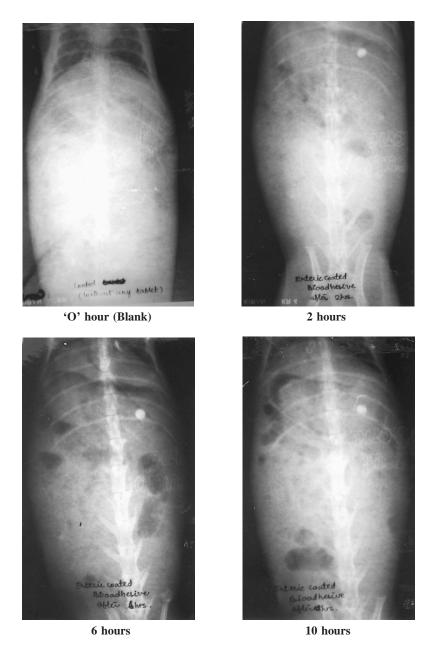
X-ray photographs taken after administering the enteric-coated bioadhesive matrix tablet.
